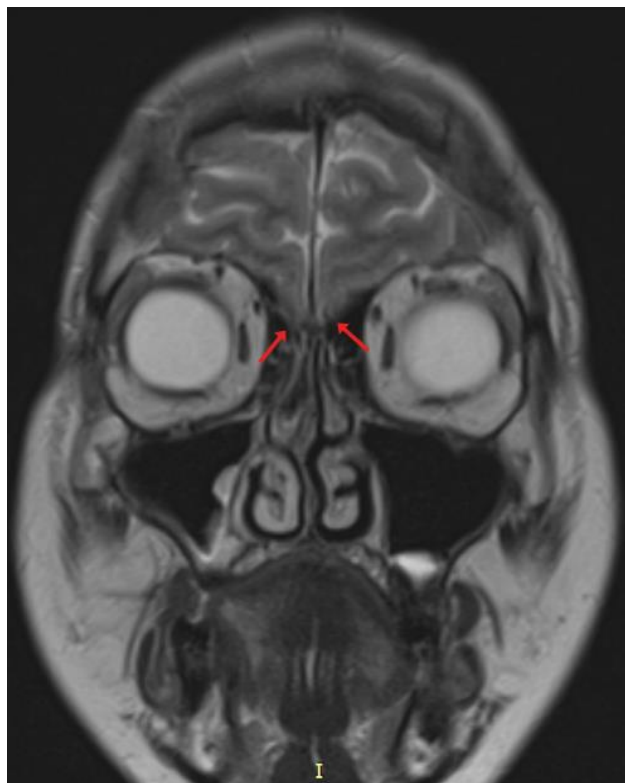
T2-weighted coronal MRI image showing olfactory bulbs hypoplasia (red arrows).
